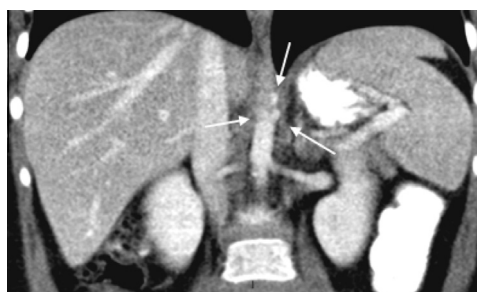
Post contrast CT of the abdomen coronal reconstruction showing separate origin of the left gastric, common hepatic, splenic arteries from the anterior aspect of the aorta (arrows).
